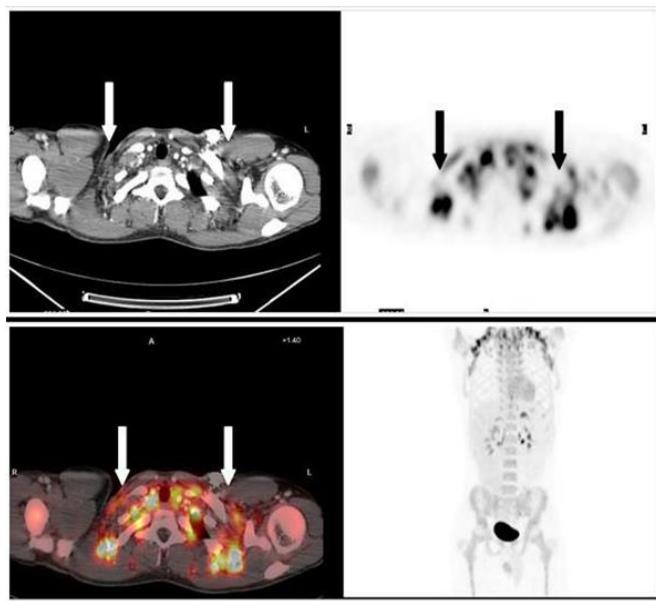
Axial CT section with intravenous contrast, axial section of the PET component, combination of both techniques and coronal section of the entire PET study. Brown fat (arrows on the different sections).
